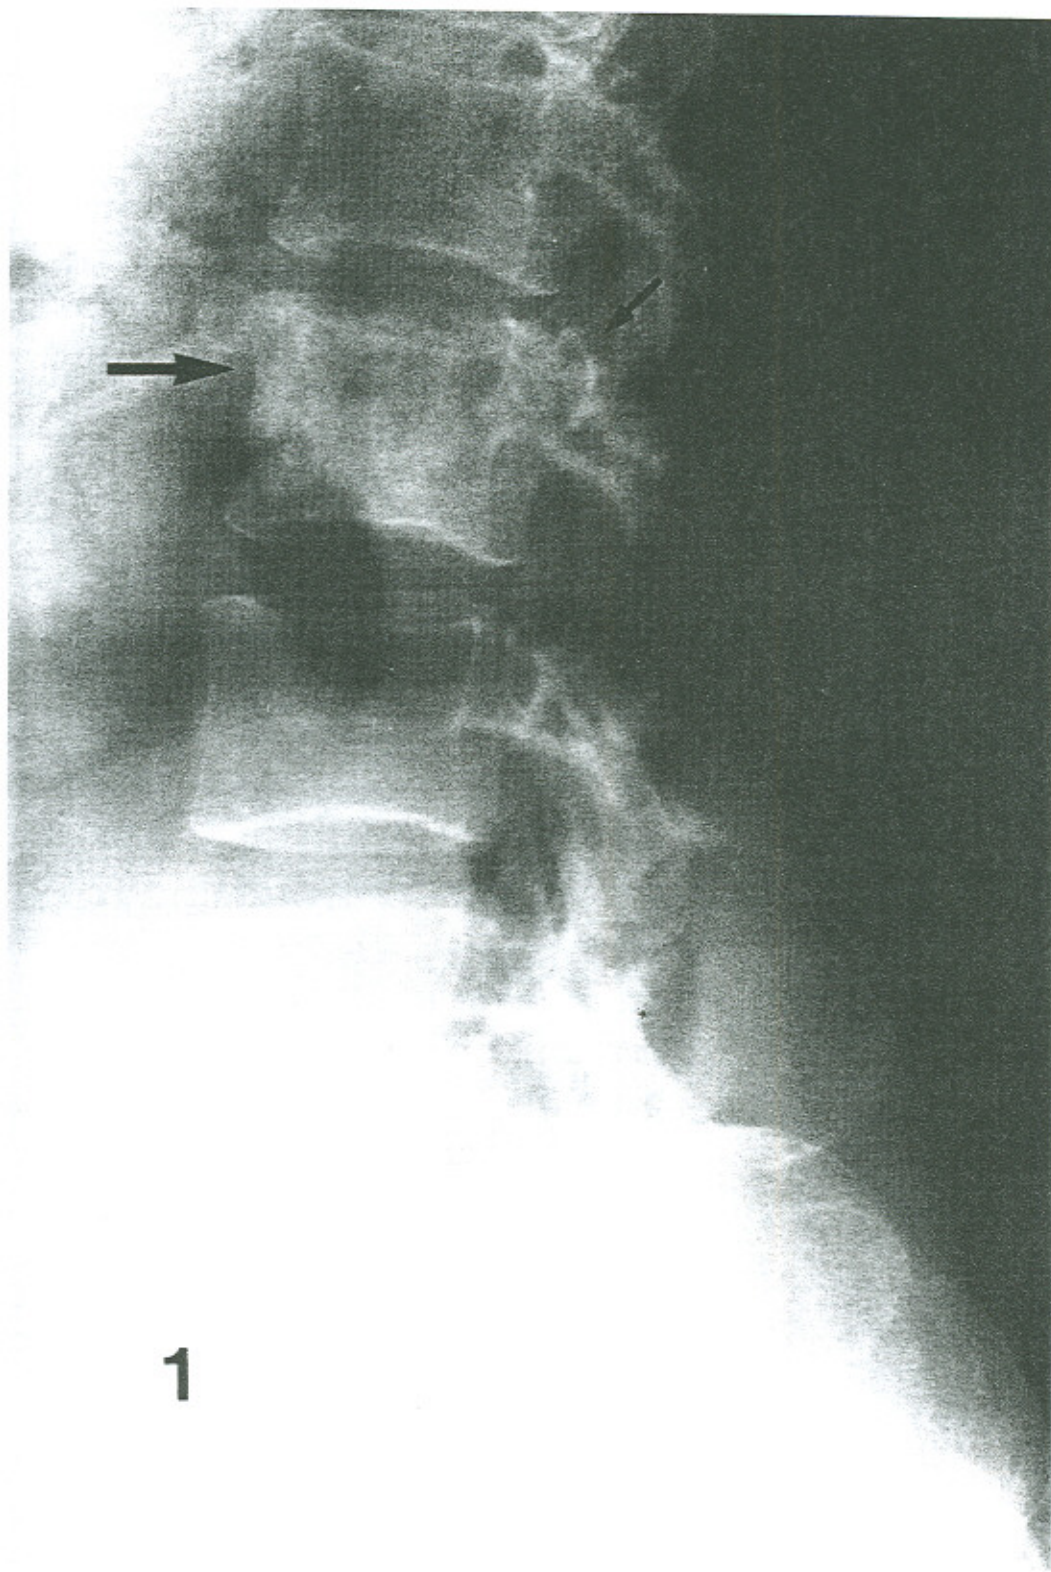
Lateral radiograph of the lumbar spine displaying patchy sclerosis of the body (large arrow) and pedicles (small arrow) of L2.
